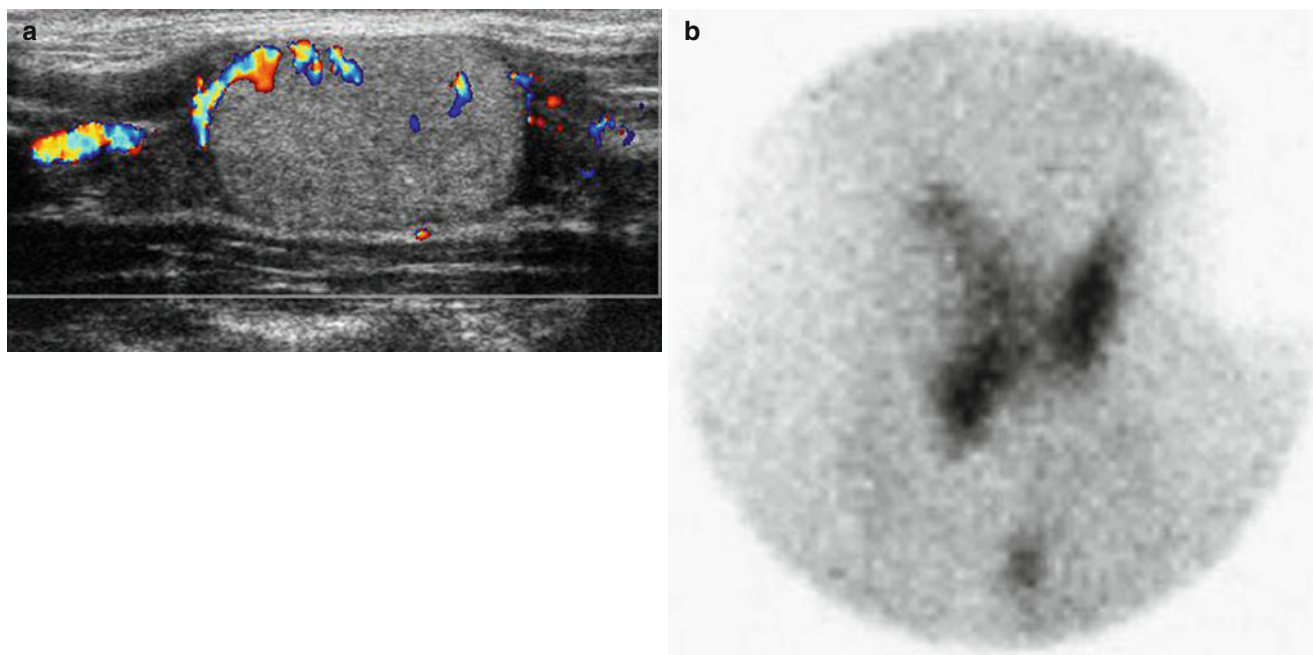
Follicular adenoma of the thyroid gland in an 11-year-old girl. (a) Color Doppler US shows a well-defined hyperechoic solid mass in the right thyroid gland. The tumor is completely surrounded by a hypoechoic peripheral halo and shows no demonstrable calcification
